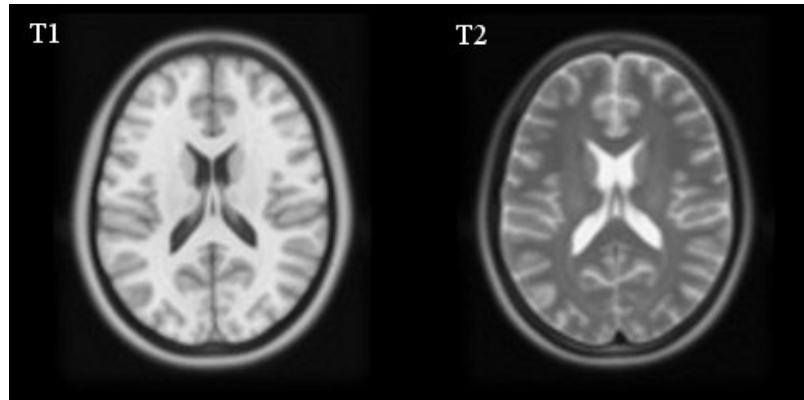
Examples of T1- and T2-weighted MR scans.
